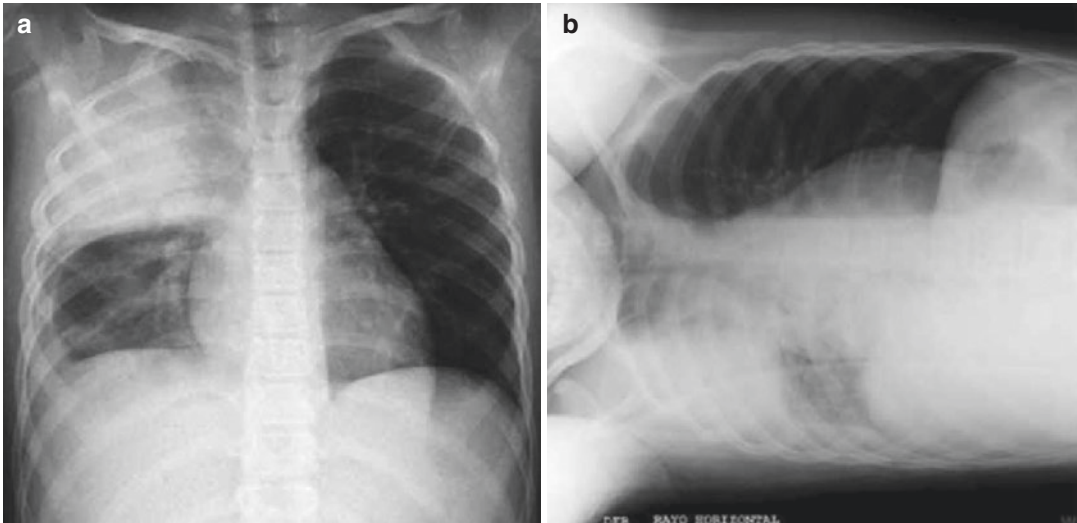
(a) Pleural effusion. Chest X-ray of 8-year-old schoolchild presenting with high fever for 48 h showing a consolidated pneumonia in right upper lobe, costophrenic recess obliteration, and pleural meniscus sign. (b) Chest
